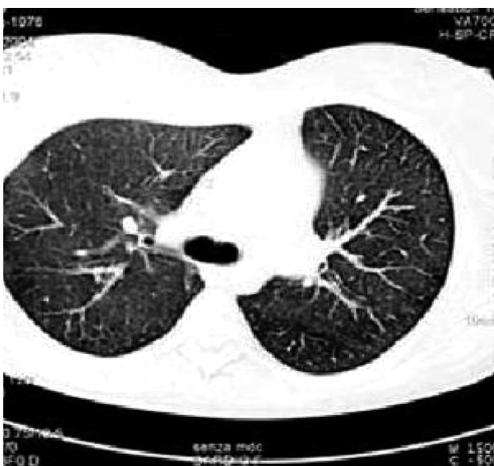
Chest computed tomographic scan confirming complete resolution of the interstitial infiltrate.
